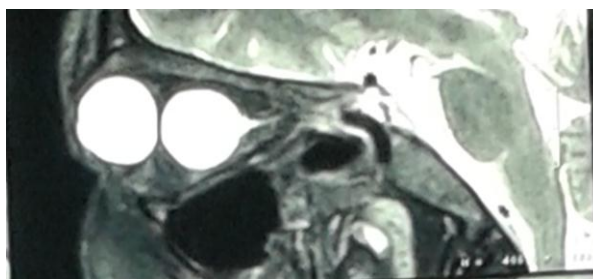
Sagittal view of Brain MRI with contrast.
